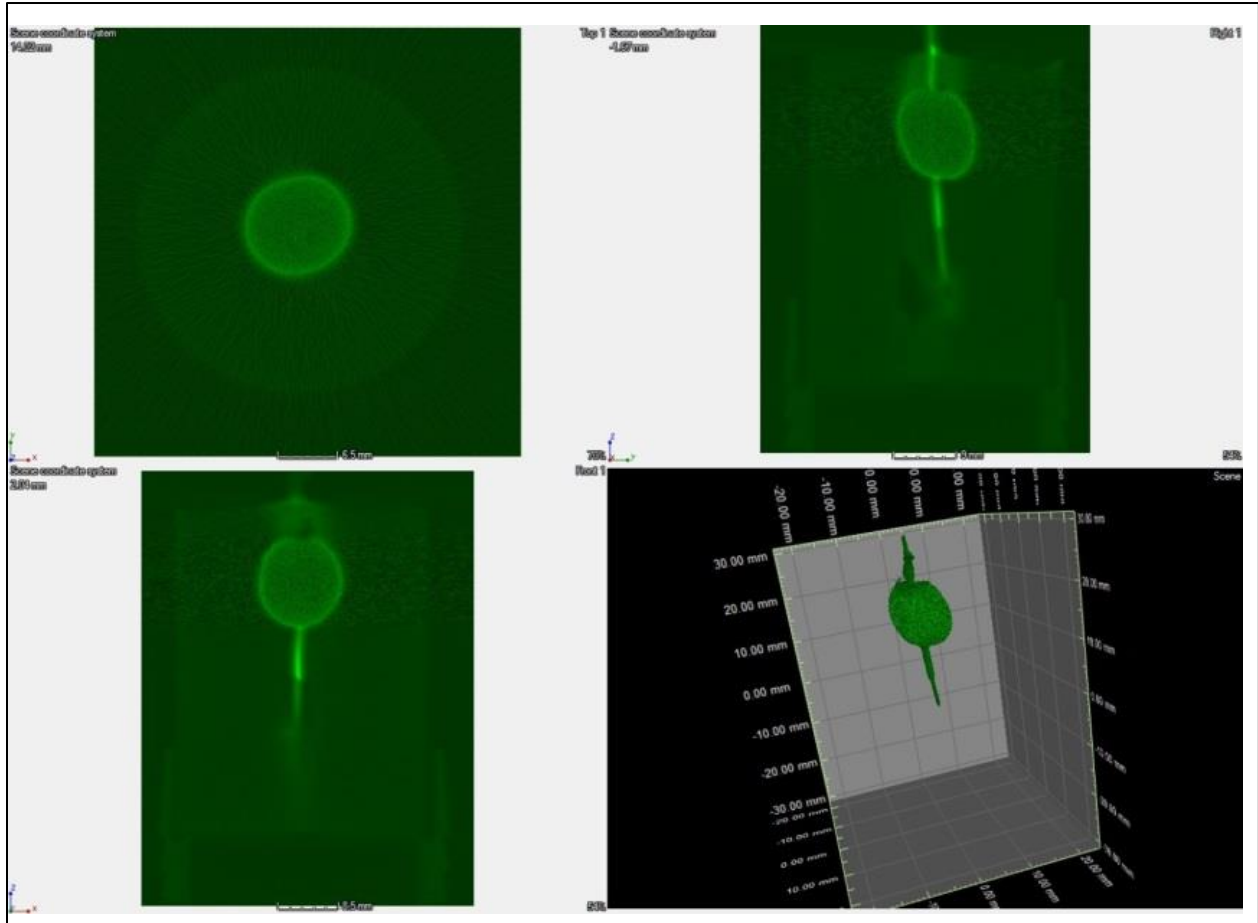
X-ray image of the balloon injected with a sodium iodide solution inside a hydrogel sample
